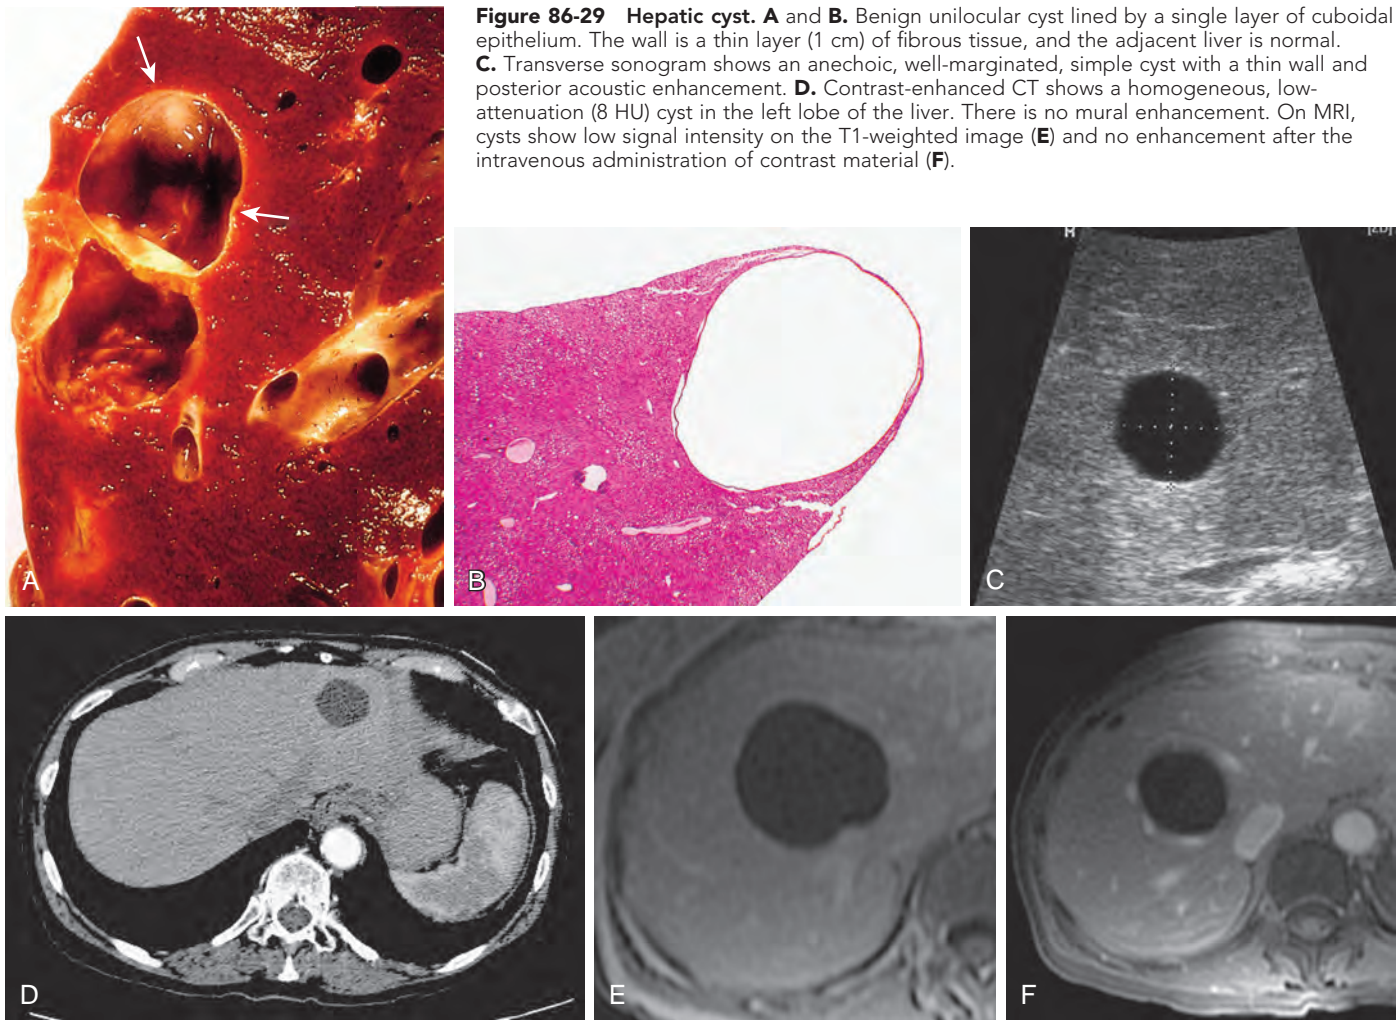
Hepatic cyst. A and B. Benign unilocular cyst lined by a single layer of cuboidal epithelium. The wall is a thin layer (1 cm) of fibrous tissue, and the adjacent liver is normal. C. Transverse sonogram shows an anechoic, well-margined, simple cyst with a thin wall and posterior acoustic enhancement. D. Contrast-enhanced CT shows a homogeneous, low-attenuation (8 HU) cyst in the left lobe of the liver. There is no mural enhancement. On MRI, cysts show low signal intensity on the T1-weighted image (E) and no enhancement after the intravenous administration of contrast material (F).
